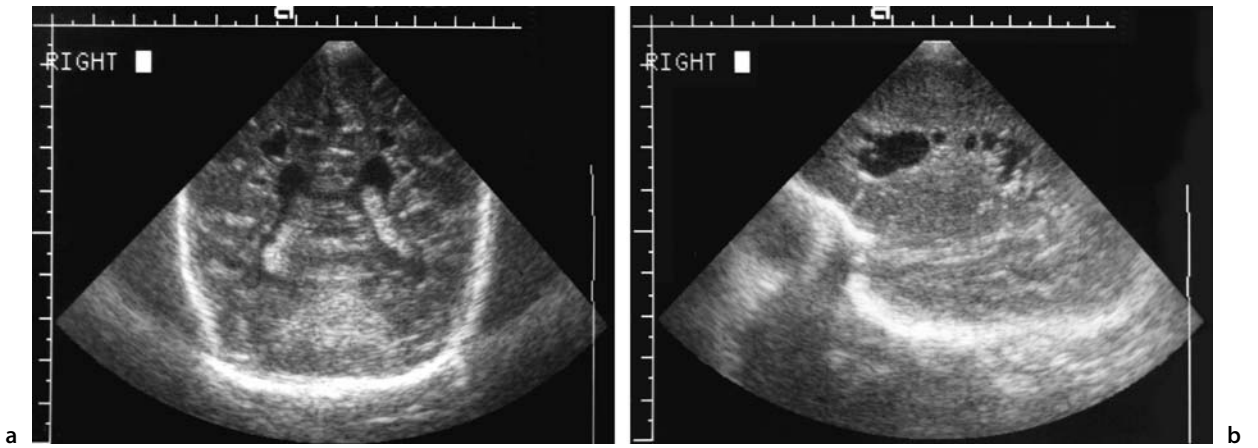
Ultrasound study of the head in a premature (26-week gestation) infant at 4 weeks of age (a, b)
